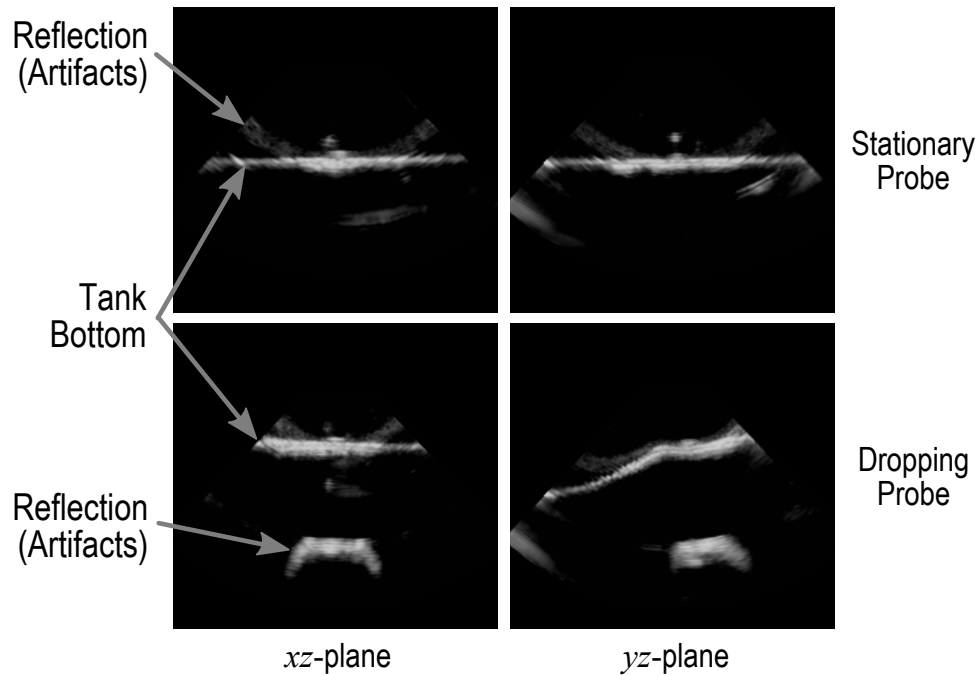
Cross sectional planes showing the bottom of the water tank while the probe was suspended and while the probe was displaced toward the bottom of the tank. The fact that the bottom of the tank appears flat in the  $xz$ -plane but curved in the  $yz$ -plane while the probe is displaced indicates the direction of acquisition of the ultrasound volume is about the  $x$ -axis.
